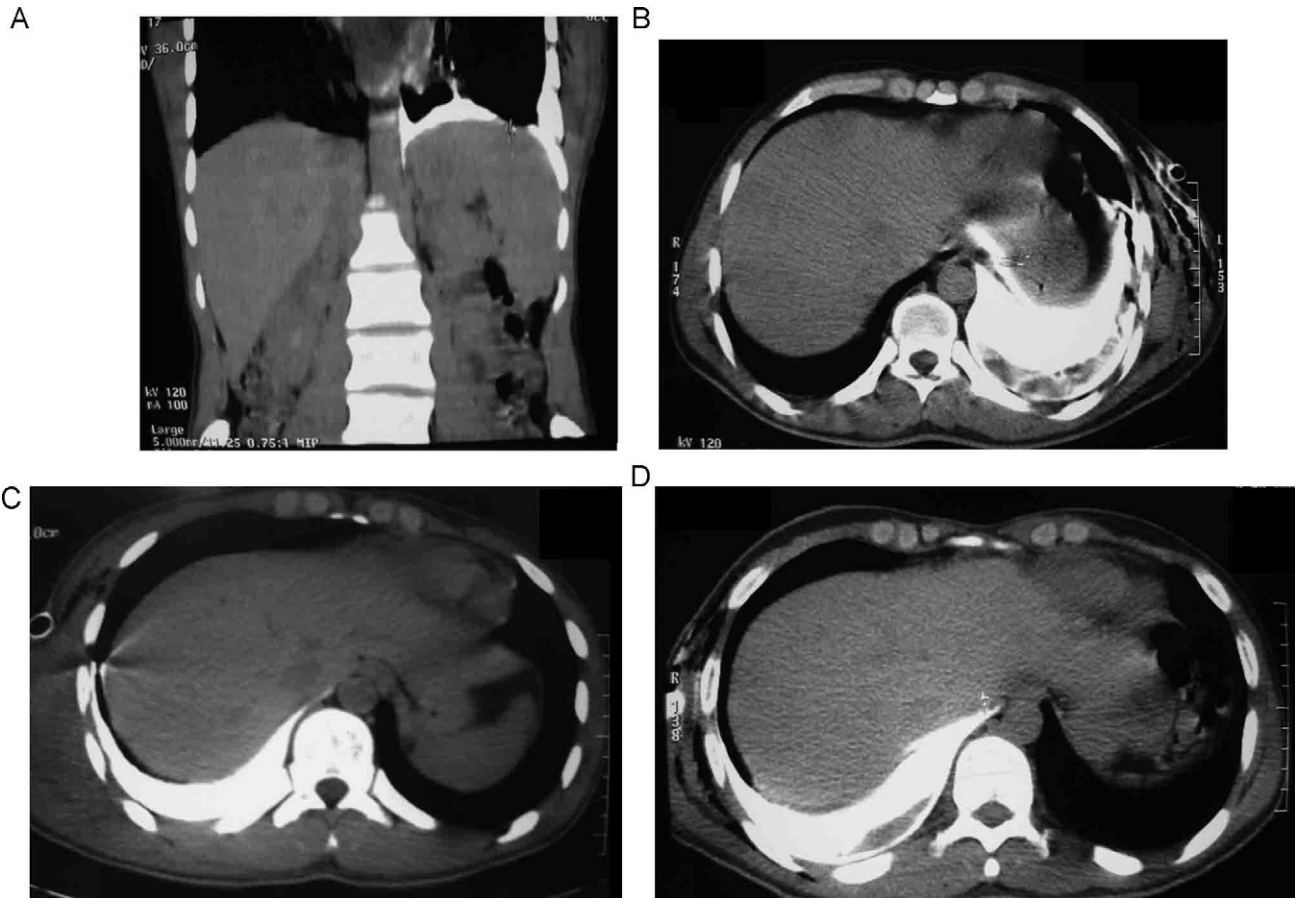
Intrapleural contrast CT-scan in 4 cases with diaphragm injury. (A) CT-scan showed a 5 mm partial tearing in the left diaphragm. (B) CT-scan showed extravasation of the contrast agent anterior to the left crus of the diaphragm and around the spleen, (C) CT-scan showed focal extension of contrast agent beneath the right crus of the diaphragm. (D) Minimal amount of contrast extravasation was seen in the suprahepatic area, anterior and parallel to the right crus of the diaphragm.
